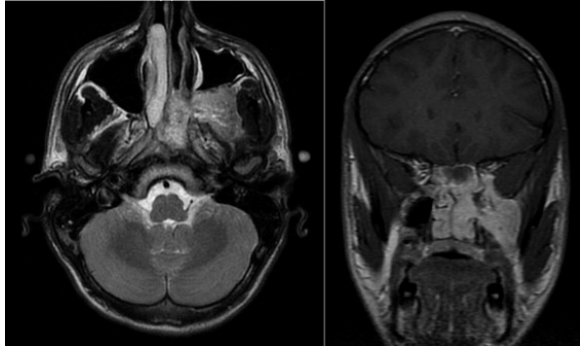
MRI Angiofibroma. T2W axial image with hyper intense signal and signal void foci. T1W coronal image after gadolinium showing large diffusely enhancing mass arising from left nasopharynx with extension to left pterygopalatine fossa.
